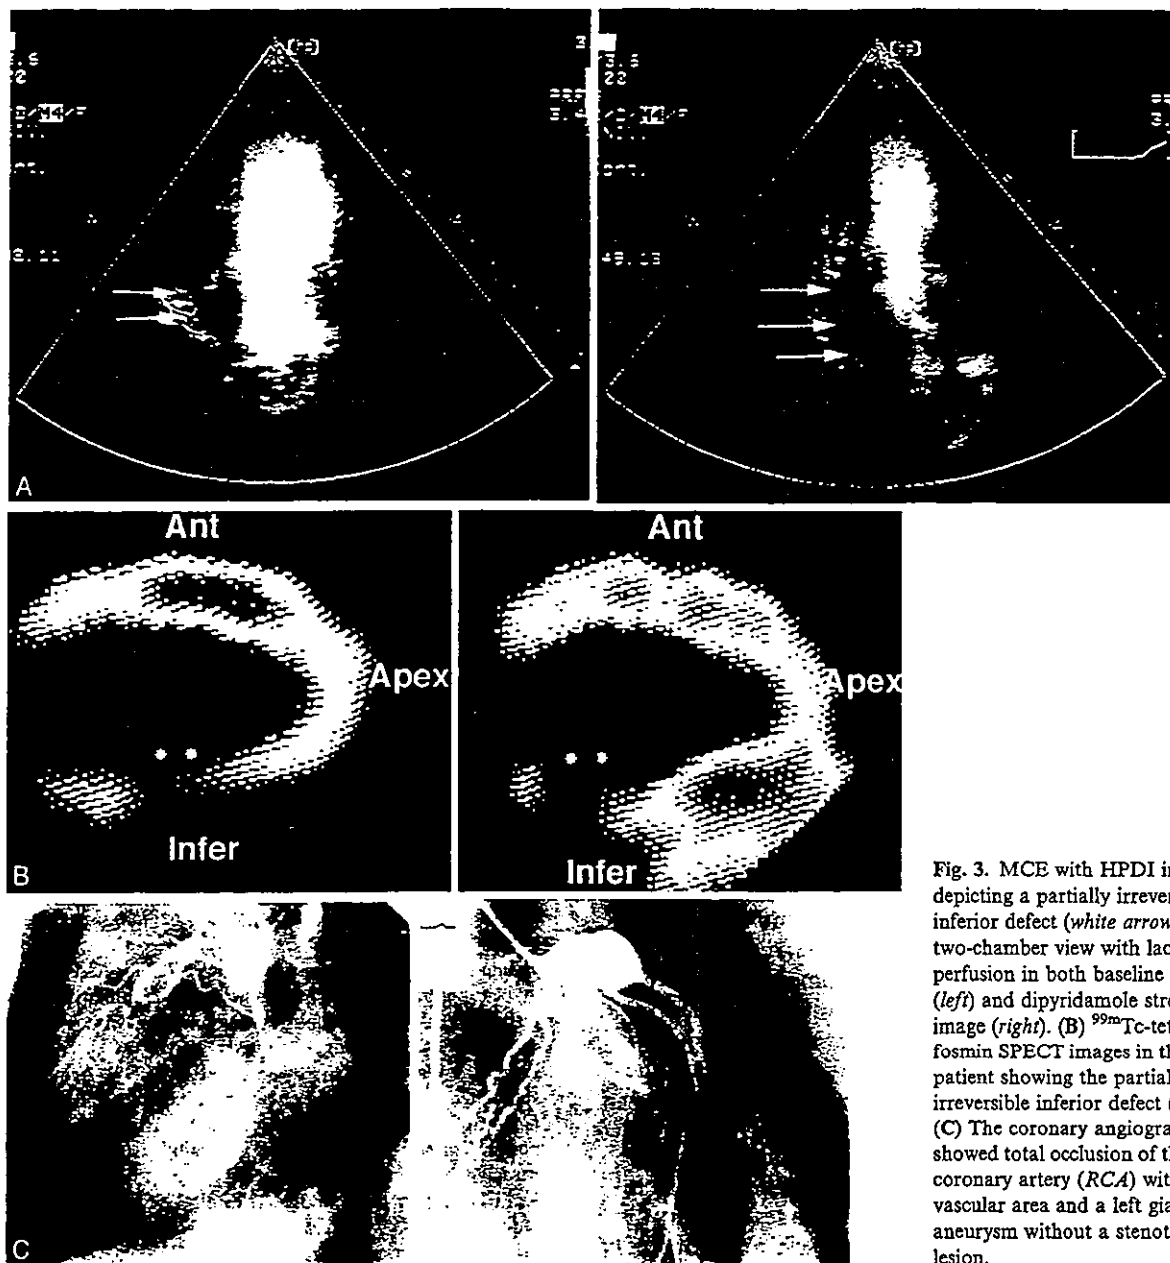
MCE with HPDI image depicting a partially irreversible inferior defect (white arrows) in a two-chamber view with lack of perfusion in both baseline image (left) and dipyridamole stress image (right). (B)  $^{99m}\text{Tc}$ -tetrofosmin SPECT images in the same patient showing the partially irreversible inferior defect (\*). (C) The coronary angiogram showed total occlusion of the right coronary artery (RCA) with a vascular area and a left giant aneurysm without a stenotic lesion.
